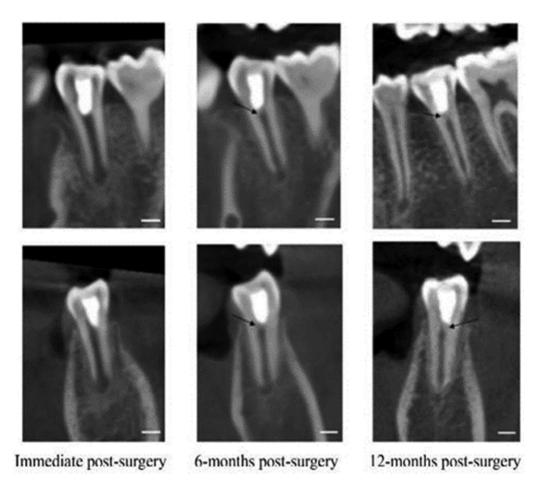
Radiographic features before and after direct pulp capping with mineral trioxide aggregate (MTA).⁴
